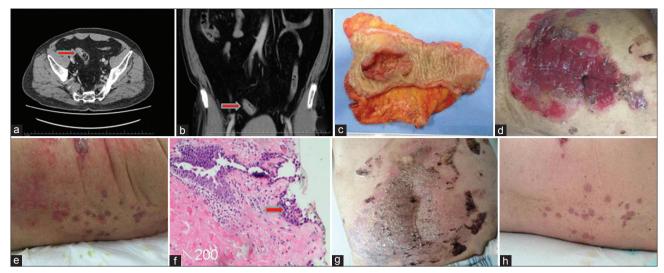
Paraneoplastic pemphigus associated with colonic cancer. (a and b) Abdomen CT before operation of the sigmoid colonic cancer. Where the arrows indicated the sigmoid colonic cancer shown in the abdomen CT. (c) Radical excision sample of the sigmoid colonic cancer. (d and e) Ulcerated and bullous lesions in the skin 3 weeks after operation, suggested the paraneoplastic pemphigus. (f) Skin biopsy pathology (HE, original magnification ×200), where the arrow showed suprabasal split with an intense lichenoid infiltrate. (g and h) After prednisone treatment, the dermatic lesions recovered 4 weeks later. CT: Computed tomography.
